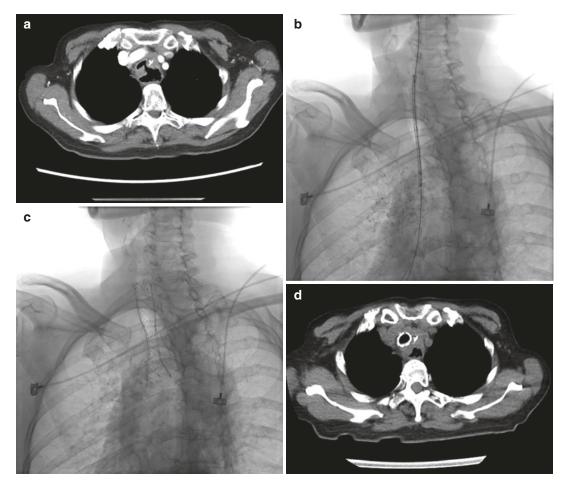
Stenting procedure for thoracostomach–airway fistula. (a) Preoperative chest CT shows thoracostomach–airway fistula. (b) Tubal coated airway stent is
